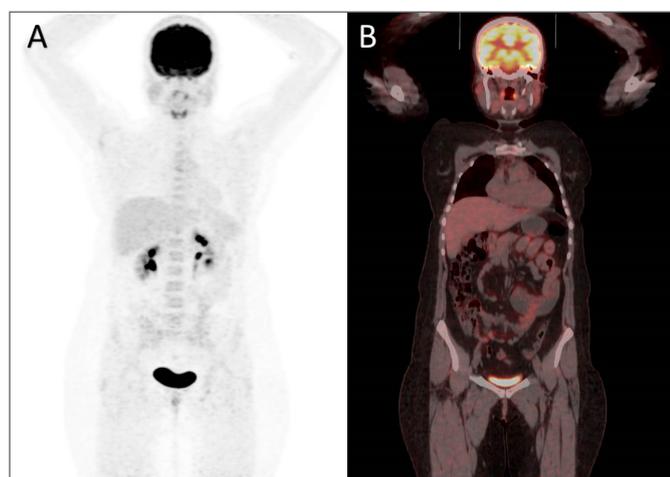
32 year old woman with breast cancer using iv PPI before imaging; FDG uptake in the stomach and intestines was less than in the liver (Visual score: Grade 1).
